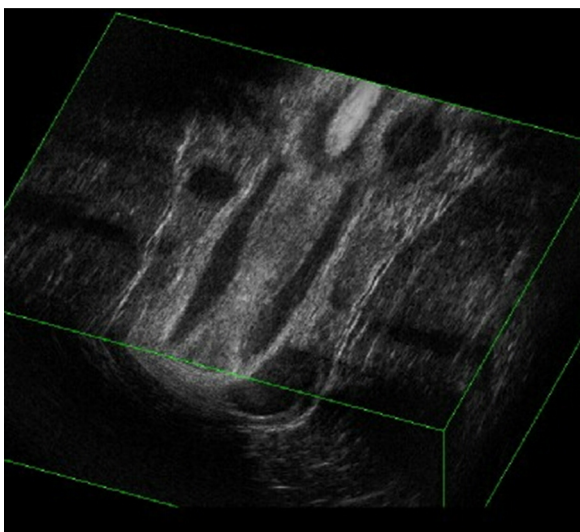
Endorectal ultrasound showing the migrating gatekeepers.
